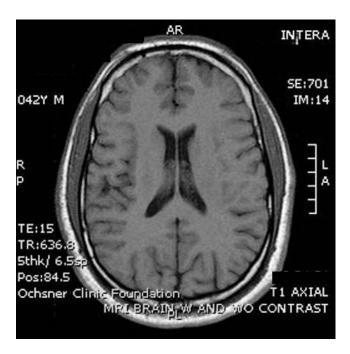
Normal magnetic resonance imaging at onset of neurologic symptoms in patient after 13 cycles of pemetrexed.
